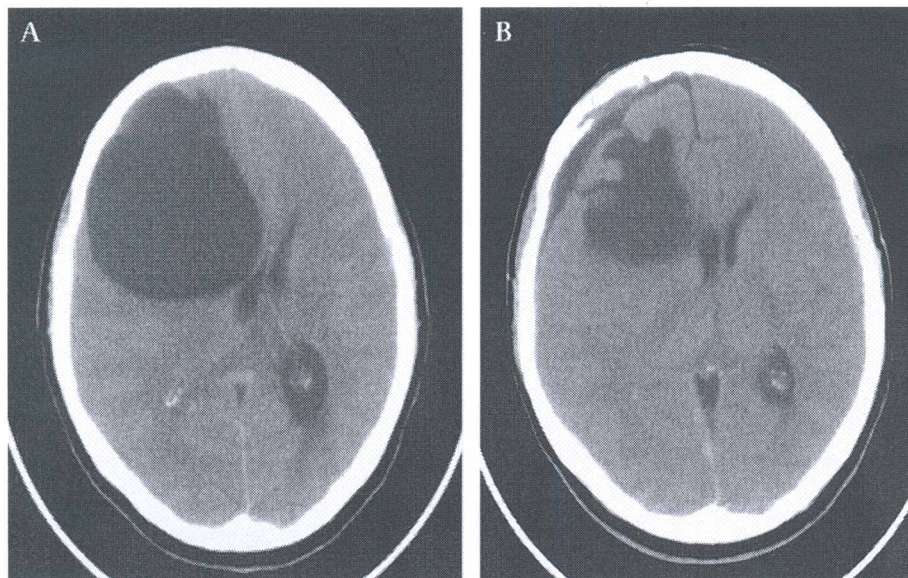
Preoperative (A) and postoperative (B) brain CT scan of the patient. Non-contrast computed tomography (CT) demonstrating a large arachnoid cyst before (left) and after (right) its surgical treatment. The image before surgery also shows right basal ganglia compression associated with marked midline shift.
